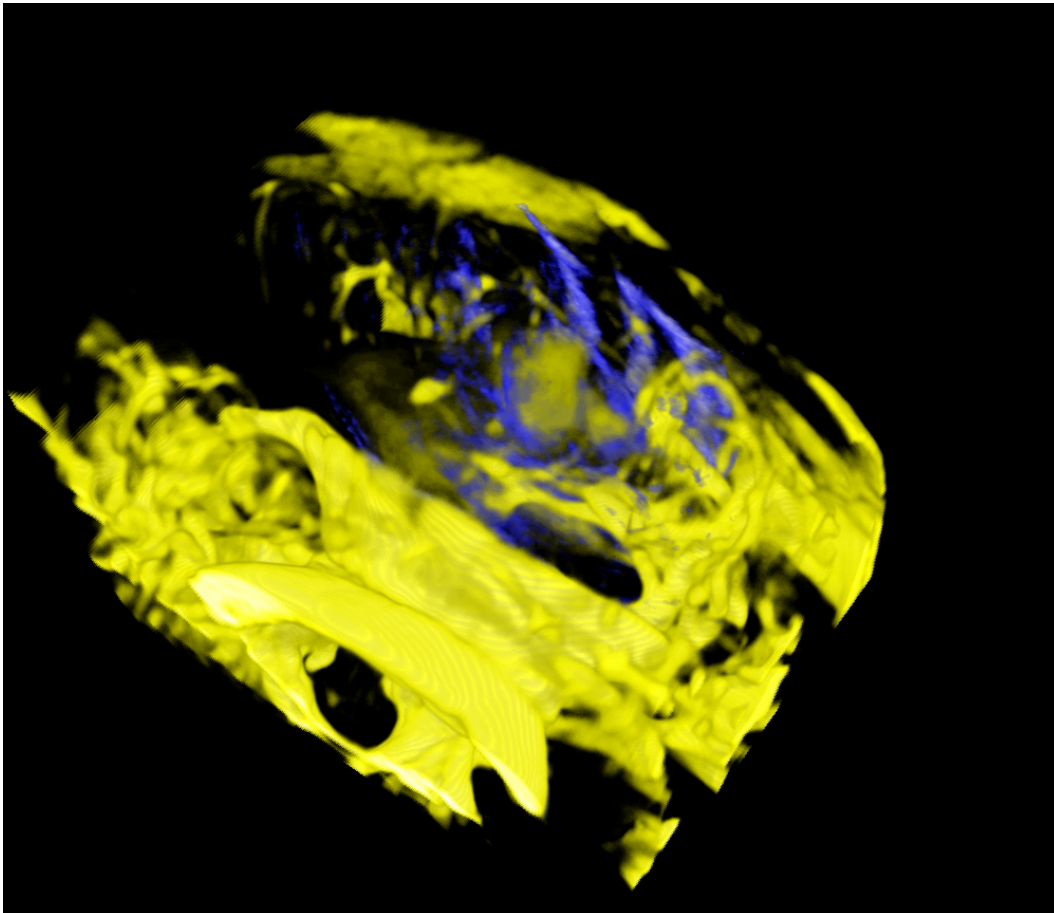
Results Tumor 1, phase 2. Volume renderings of UST (*blue*) and MRI T2 (*yellow*) after registration.
